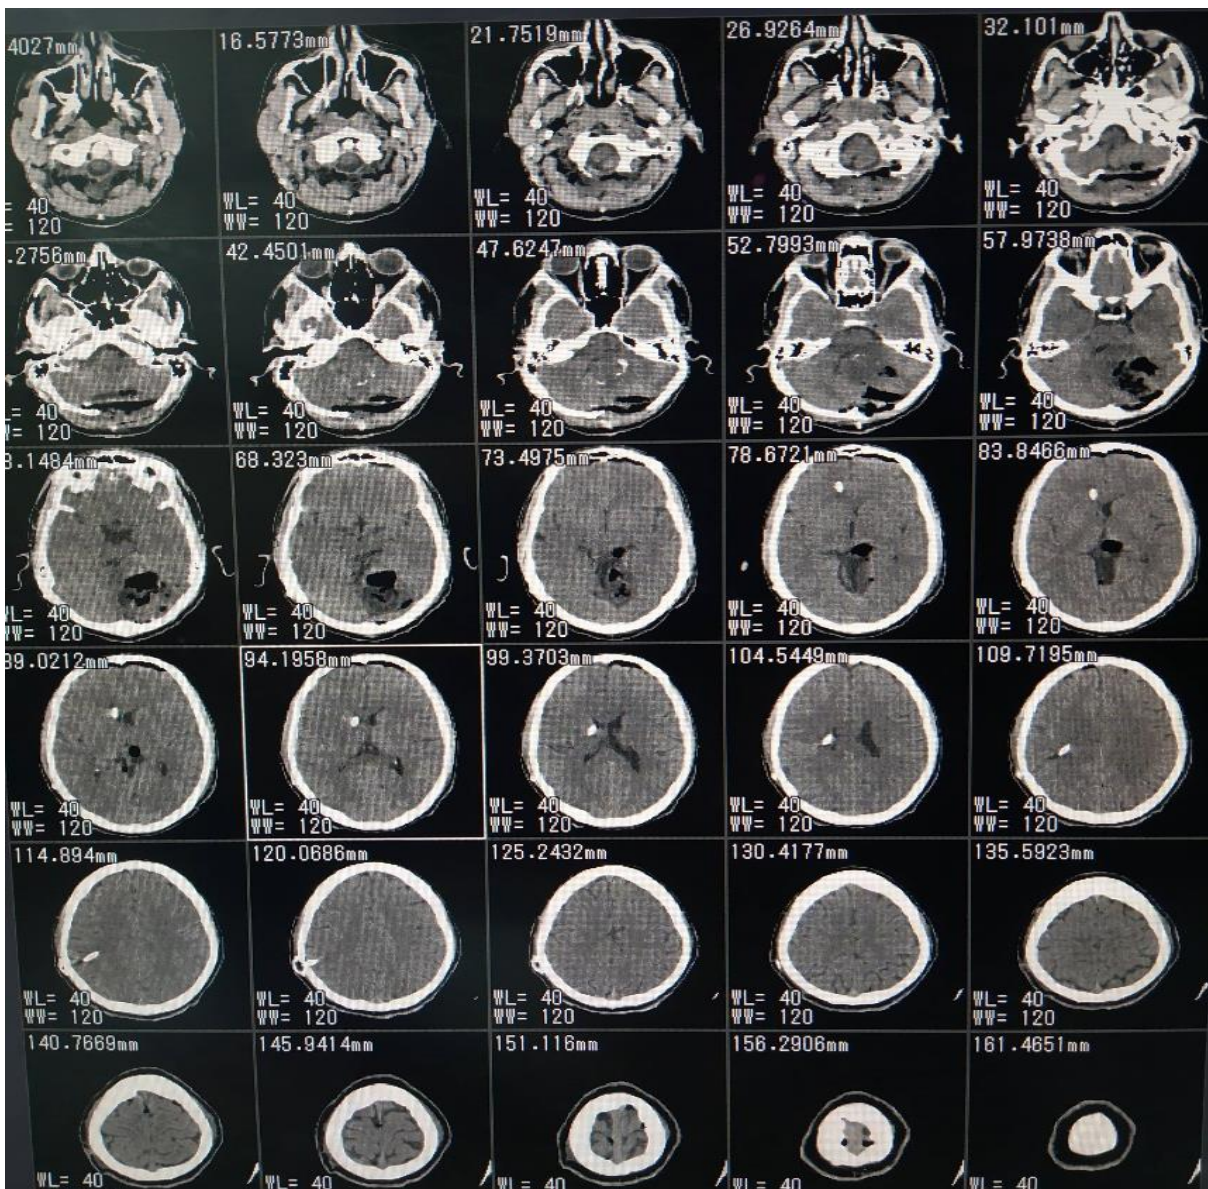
CT scan immediate post-operative tumor resection, axial view.
